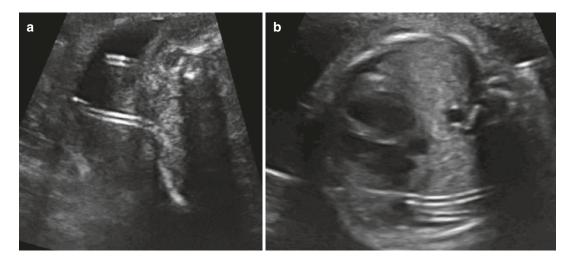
ultrasound images after thoraco-amniotic shunt placement. (a) On the left the free part in the amniotic cavity is seen, and (b) on the right the intra-thoracic part. Image: courtesy UZ Leuven
